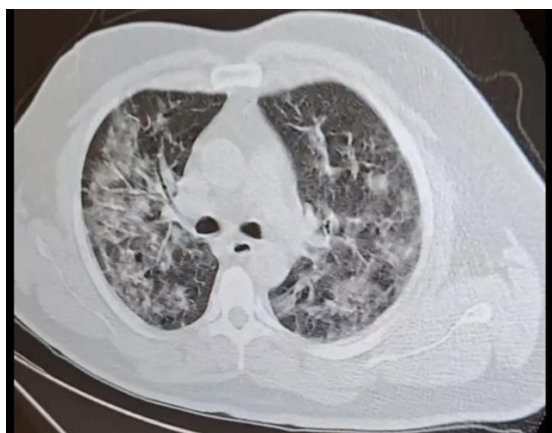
patient's HRCT scan indicating bilateral ground glass opacities with reticulation and interlobular septal thickening
